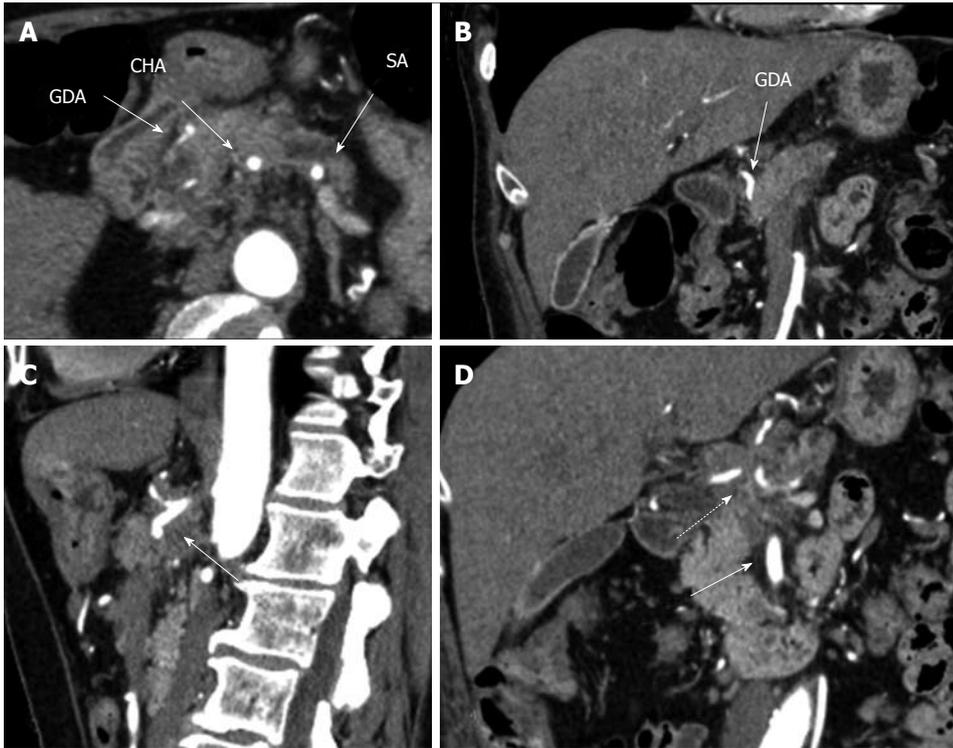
Preoperative computed tomography. Arterial phase. A: Axial image. The common hepatic (CHA) and splenic (SA) arteries present circumferential adjacency to pancreatic body ductal adenocarcinoma. The gastroduodenal artery (GDA) appears to be completely encircled by tumor; B: Frontal view. Computed tomography (CT) evidences circumferential infiltration of GDA; C: The celiac artery (CA) along with CHA springing from it, are completely circumscribed by tumor (arrow); D: All three CA branches (dashed arrow) show circumferential tumor contact. The superior mesenteric artery is unaffected (arrow).
